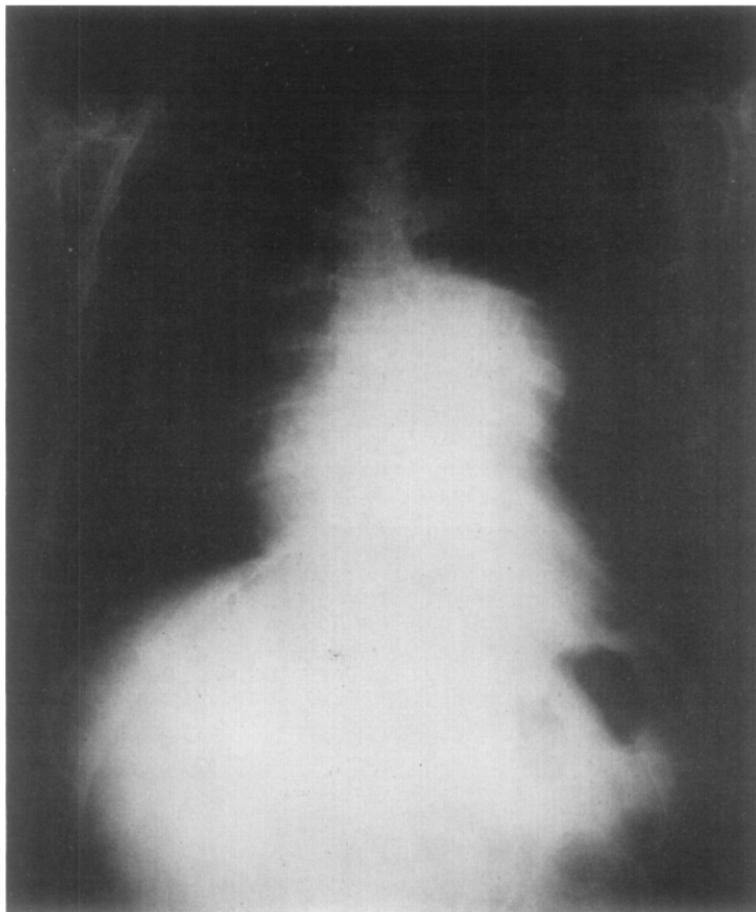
An ordinary x-ray film of a patient with an aneurysm of the left sinus of Valsalva which compressed the pulmonary infundibulum.
